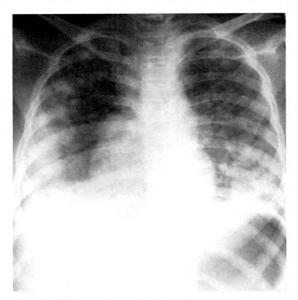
Case III. Anteroposterior roentgenogram made with a portable unit approximately 24 hours after surgery shows diffuse pulmonary abnormality but with much greater involvement in the lateral periphery of the lungs.
